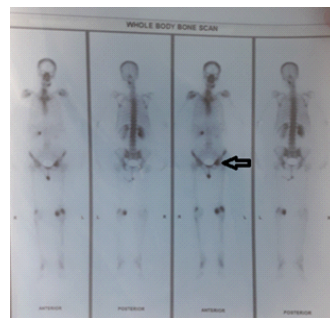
Bone scintigraphy showing a bone metastasis in the left hip joint
